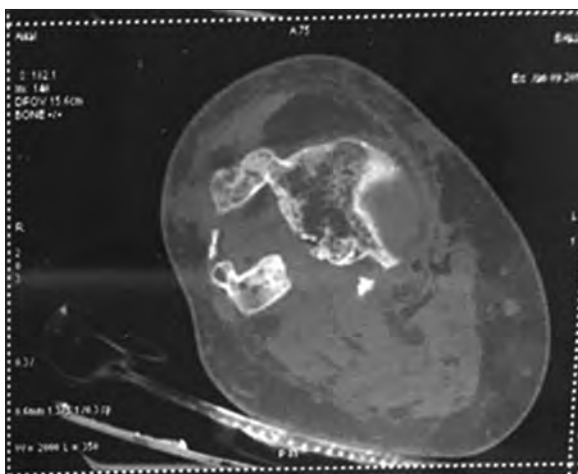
Pre-op Axial CT
